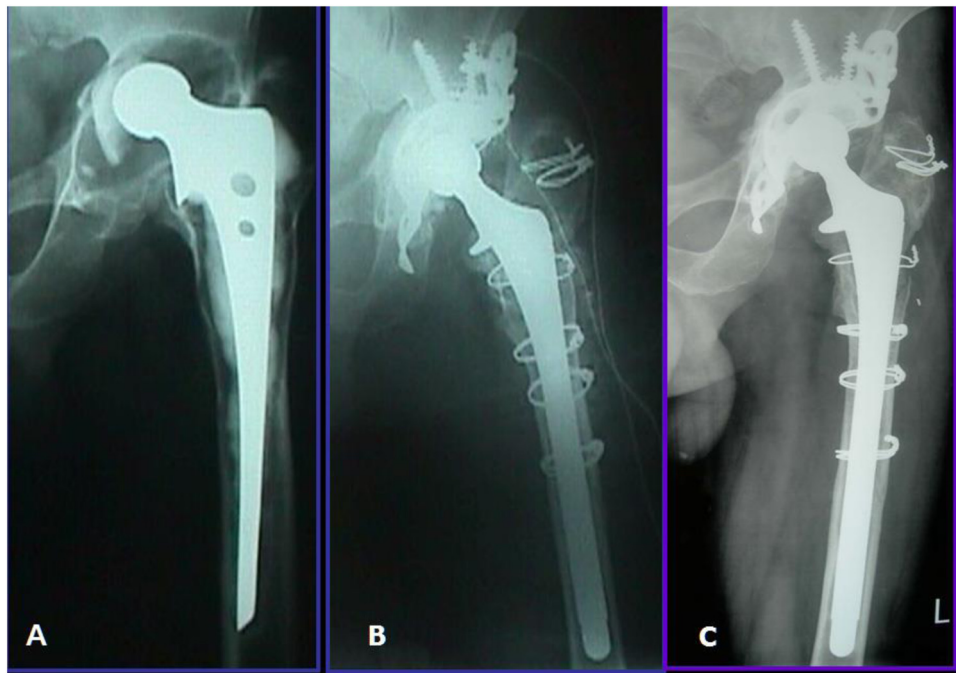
(A) Aseptic loosening 16 years after primary THA with a grade IIIB Paprosky defect (B) Postoperative radiograph after revision with a Wagner stem (C) Radiograph at 10 years follow-up showing good osseointegration and a healed, consolidated osteotomy.
